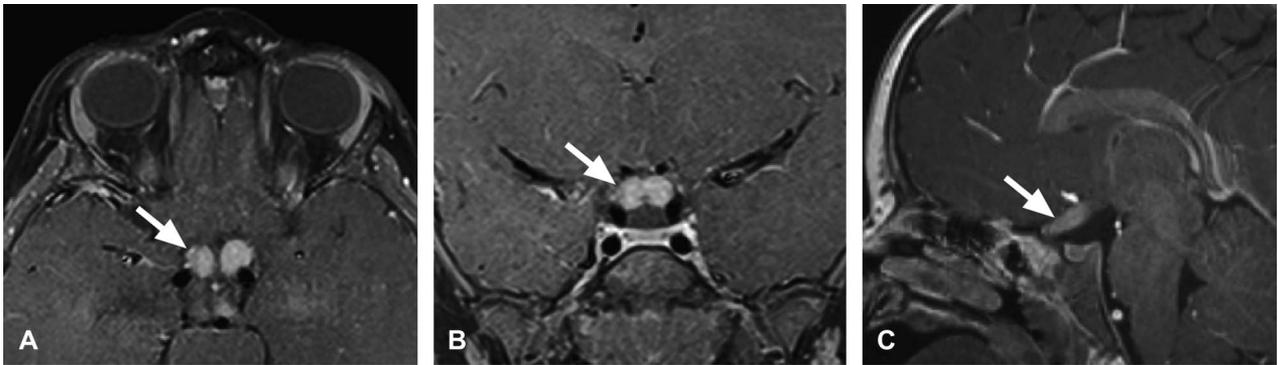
Contrast-enhanced axial (A), coronal (B), and sagittal (C) MRI demonstrates thickening and enhancement of the junction of the chiasm and intracranial optic nerves (arrows) consistent with an OPG.
